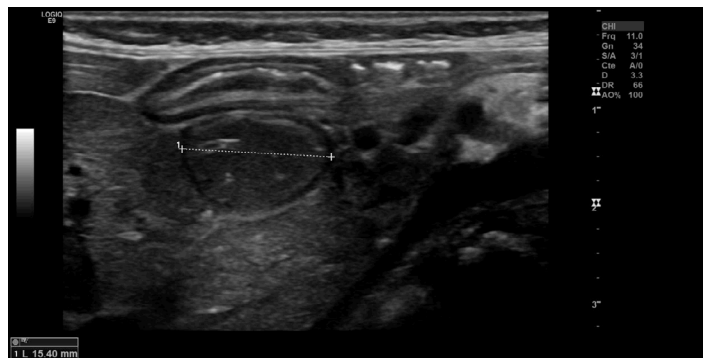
A second abdominal ultrasound showed an inflammatory aspect of antro-pyloric region associated with a non-vascularized hypo-echogenic mass.
